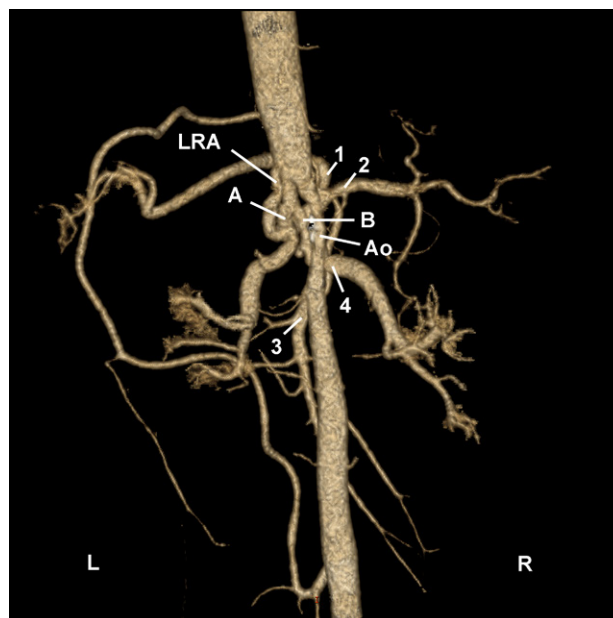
Computed tomographic angiogram of the abdominal aorta (posterior view) shows the visceral arteries. “A” indicates the anomalous celio-mesenteric trunk, which continues as the celiac artery proper and then gives rise to the splenic artery (1) and common hepatic artery (2). “B” indicates a common arterial trunk that originates from the celio-mesenteric trunk and gives rise to the superior mesenteric artery (3) and right renal artery (4).
